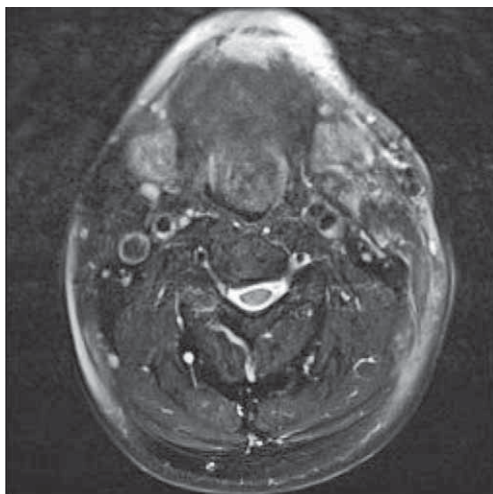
This axial T2 MRI scan shows sharply delineated high signal lesion, placed medially at the base of tongue.
